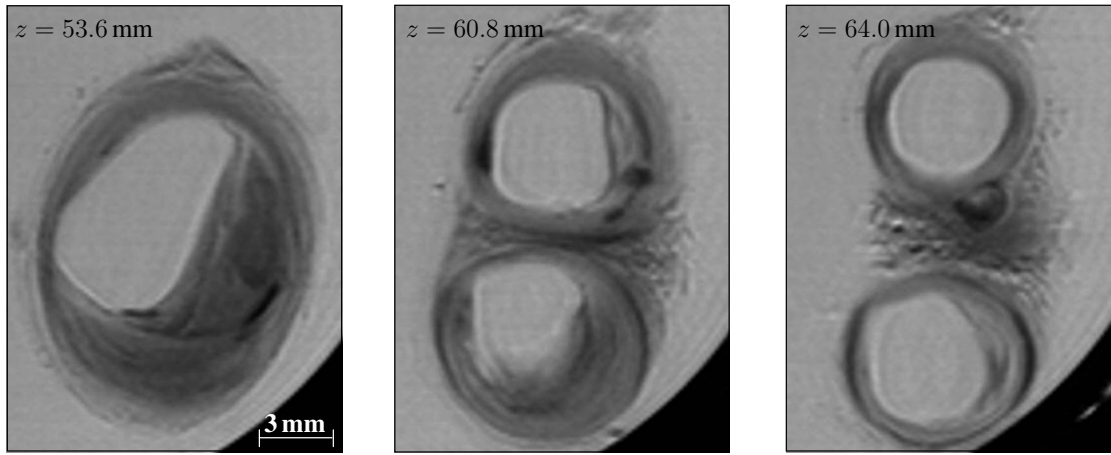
Representative T1-weighted MR images (slice thickness of 0.8 mm and in plane resolution of 0.15 mm) showing different sections of the excised human carotid bifurcation, with z referring to the coordinate system, as introduced in Fig. 2
